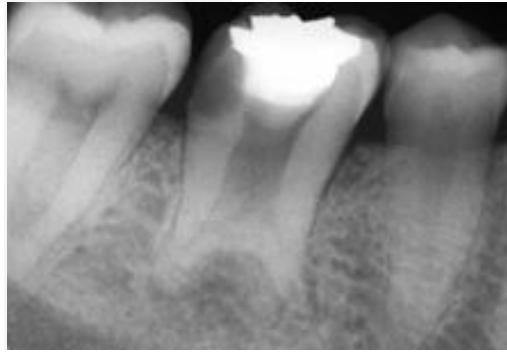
Radiograph at diagnosis
